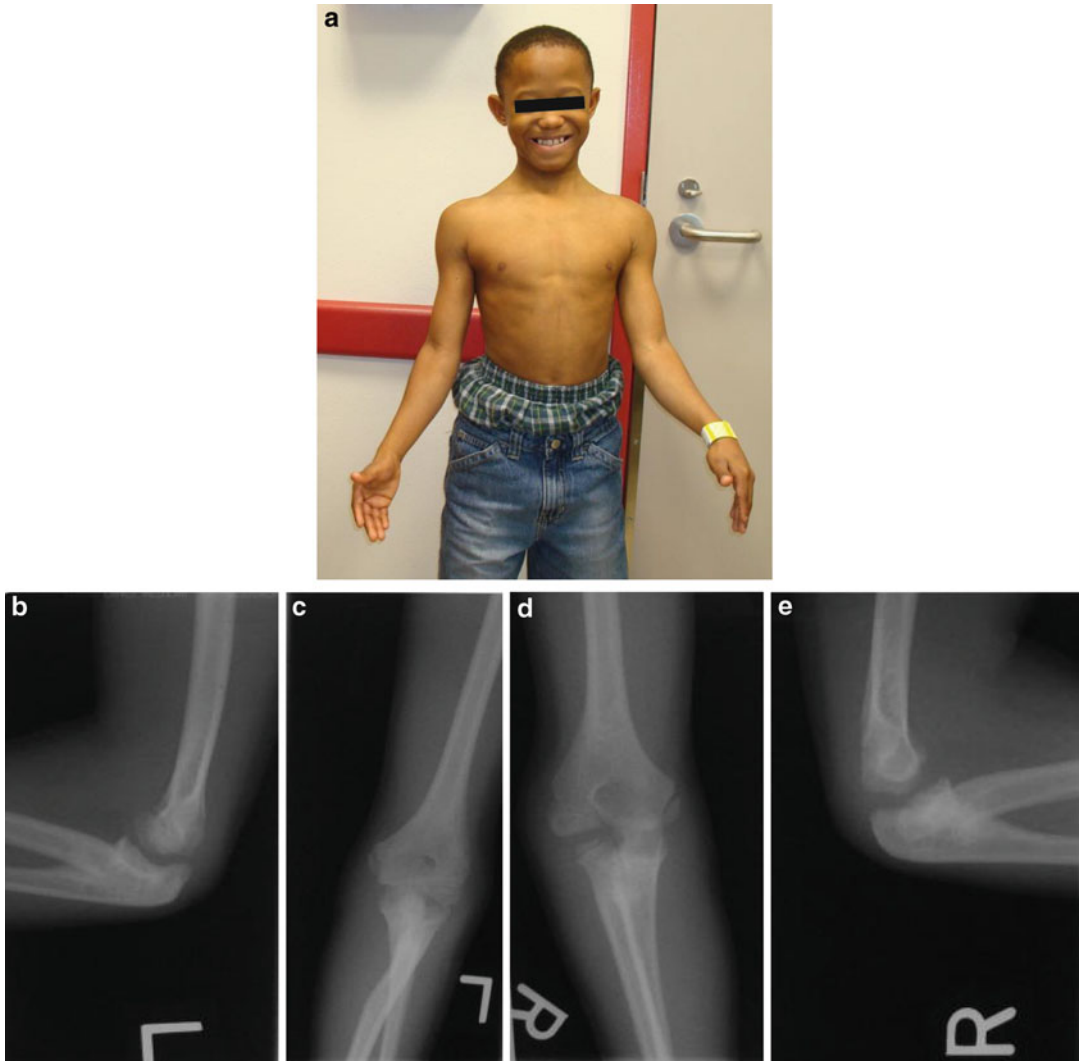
(a–e) The 10-year-old brother also had bilateral proximal radioulnar synostosis, shown by radiographs (b–e) with similar clinical features (a)
